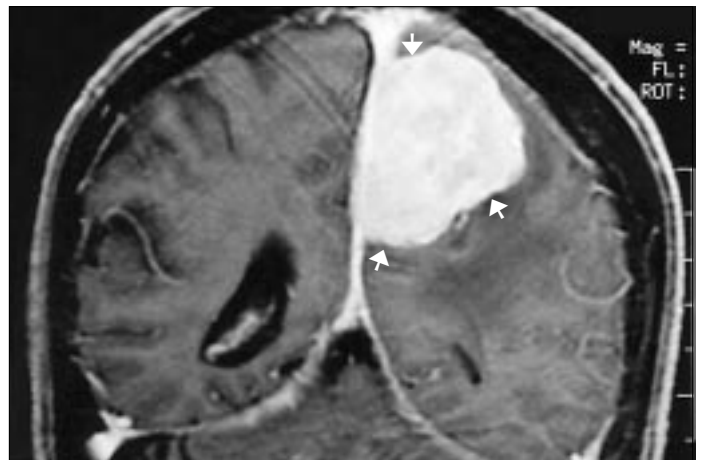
Axial T2-weighted MR image shows a left parasagittal mass (arrows) that is contiguous with the falx.
